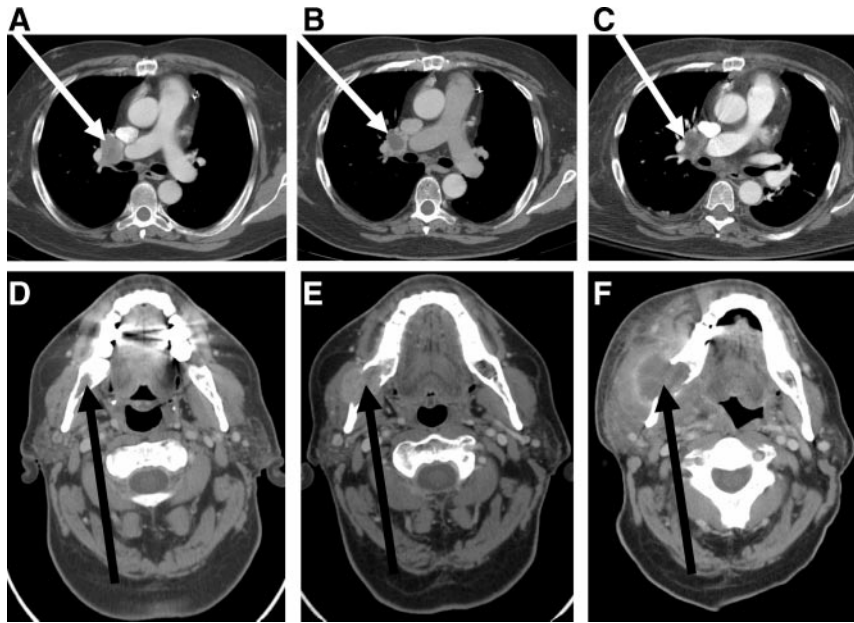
A, CT scan of the chest showing a 3.8-cm metastatic disease in a hilar lymph node (indicated by *white arrow*) at baseline (before treatment with sorafenib). B, CT scan of the chest of the same patient showing necrosis of the hilar lymph node (indicated by *white arrow*) after 2 months of treatment with sorafenib. The node now measures 3.4 cm, and the HU decreased from an average of 72 HU at baseline to 13 HU after treatment. C, CT scan of the chest with a 3.7 cm hilar node (indicated by *white arrow*) after 5 months of therapy. D, CT scan of the neck showing a small metastasis to the right mandible (indicated by *black arrow*) at baseline. E and F, CT scan of the neck showing progression of the mandibular metastasis (indicated by *black arrow*) after 2 months of treatment with sorafenib (E) and after 5 months of sorafenib (F).
